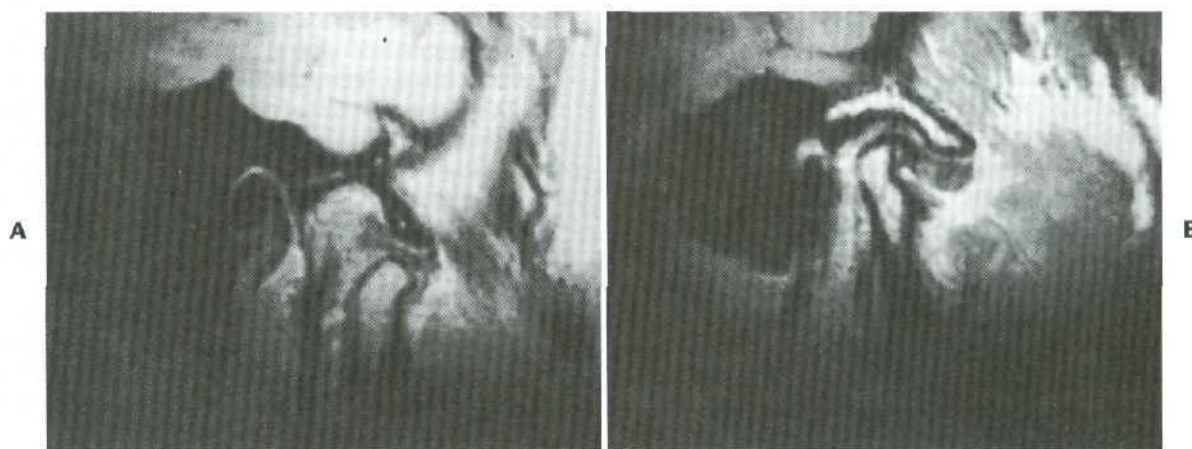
Magnetic resonance image. A, This view shows normal disk and condyle relationship in open position. B, Image demonstrates anterior disk displacement and slight bone changes on articulating surface of condyle.
